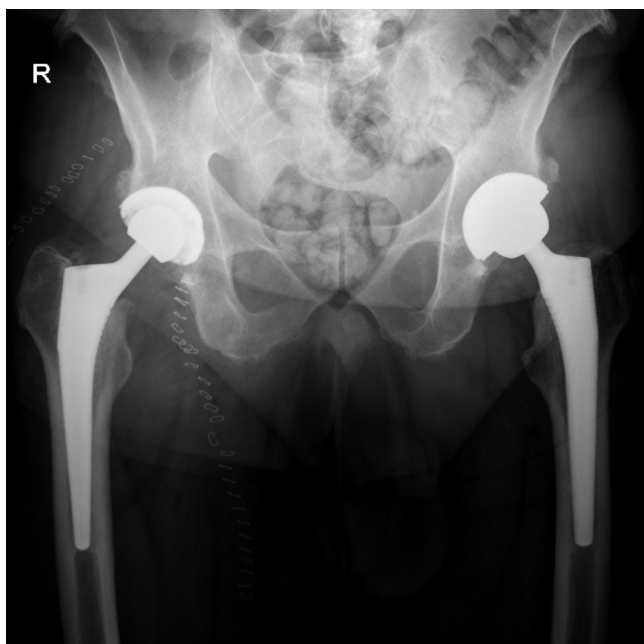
Postoperative AP pelvic radiograph showing revised head and acetabular component.
